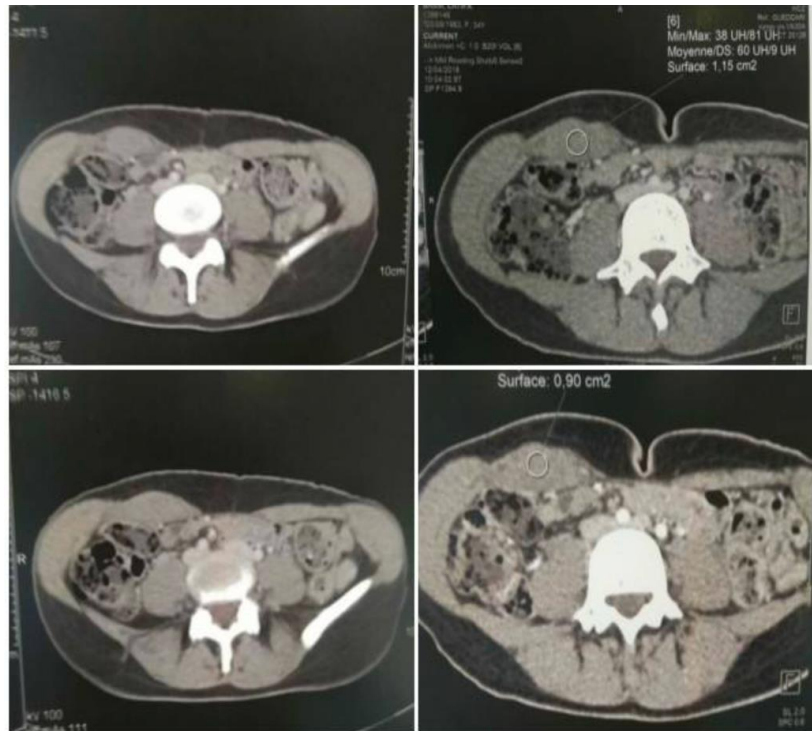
CT images demonstrating the size and location of the mass
